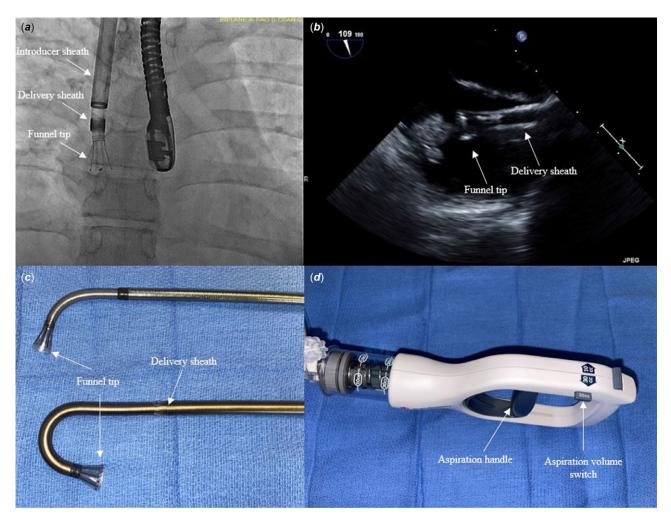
(a) Fluoroscopy of AlphaVac F18⁸⁵ system through the delivery sheath, coaxially through the 22Fr Gore DrySeal sheath positioned in the right atrium with transoesophageal echocardiogram (TEE) guidance. (b) TEE still image showing the AlphaVac funnel tip engaging thrombus. (c) F18⁸⁵ and F22¹⁸⁰ AlphaVac catheters with curved tips fully deployed through their delivery sheaths. (d) Aspiration handle with 10cc and 30cc aspiration volume settings.
